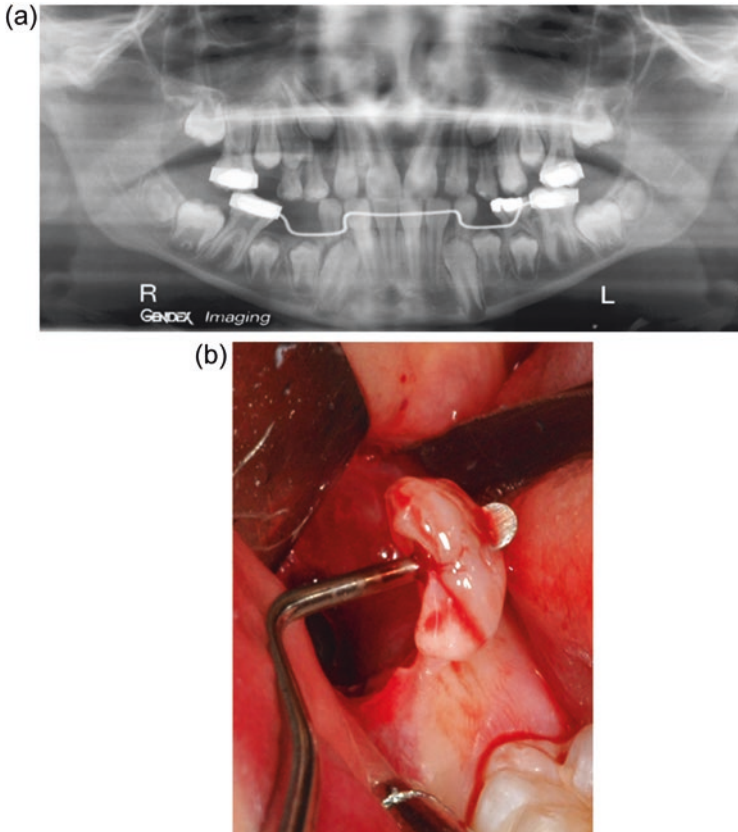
(a) Radiographic estimation of third molar bud stage; (b) third molar bud extracted
